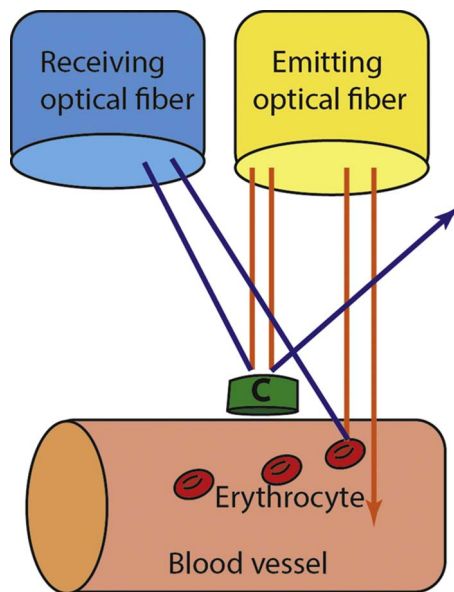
Effect of Doppler applied to laser radiation; c: immobile cell.
